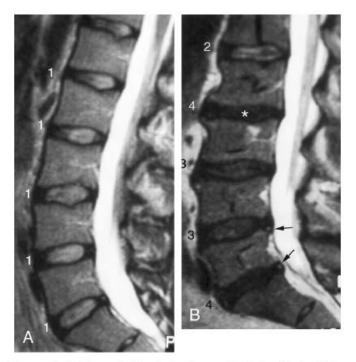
A, Normal disc hydration and height. Sagittal T2weighted image demonstrates normal disc signal and height (rated as 1 [normal] on a 1–4 scale). B, Sagittal T2-weighted image demonstrates mild (2), moderate (3), and severe (4) desiccation. Also note height loss at L2–L3 (\*) and anular tears seen as linear high signals at L4–L5 and L5–S1 (arrows).
